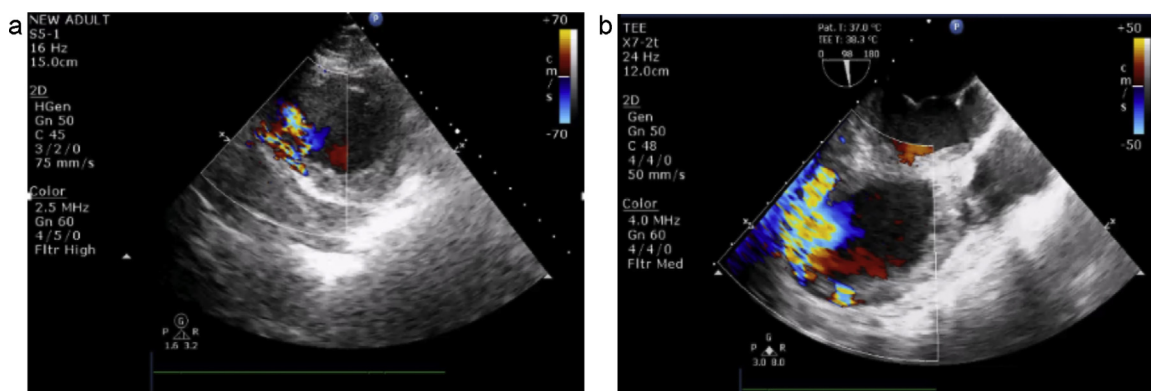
(a) PSAX and (b) transesophageal echocardiogram showing the VSR in a patient with AWMI.
